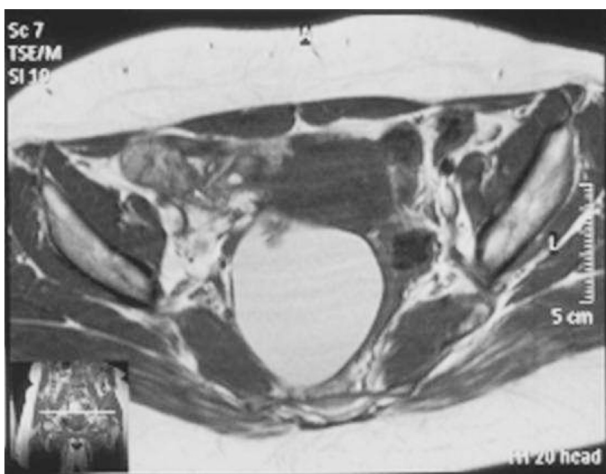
Magnetic resonance imaging with T1-weighted sequences in axial view.
